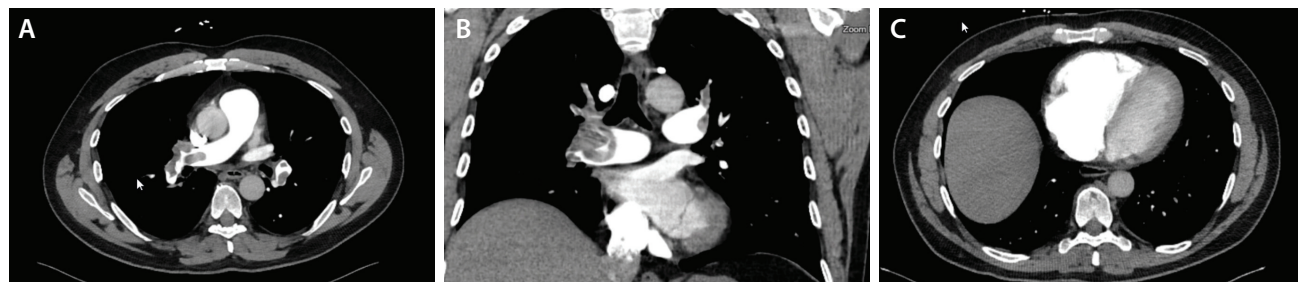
Pretreatment CTA demonstrating extensive bilateral PE and signs of RV pressure overload. Axial CTPA showing large, centrally located thrombi involving the right main PA with extension into the lobar and segmental branches of the right lower lobe (A). Coronal reformatted CT images confirming extensive thrombus burden in the right PA system, predominantly involving the lower lobe vasculature, with reduced distal perfusion (B). Axial cardiac CT image demonstrating marked RV dilation with septal bowing consistent with elevated RV systolic pressure; the calculated RV/LV ratio was 1.7, indicating significant right heart strain (C).
